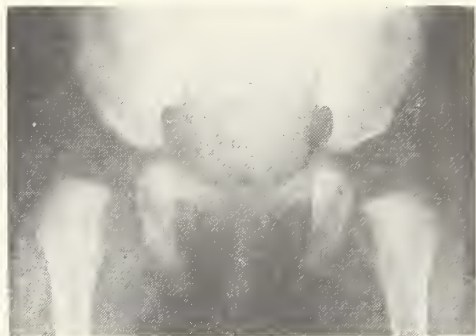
Roentgenograms of a six month old infant with right hip dislocation. The acetabular roof is shallow, there is delayed ossification of the femoral head, and the upper end of the femur appears displaced laterally and upwards.
